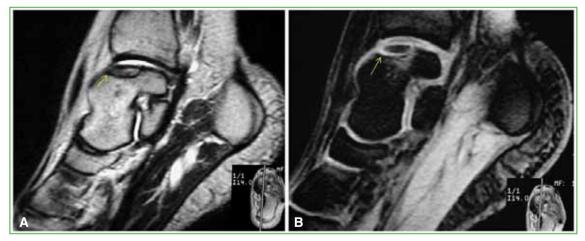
Sagittal T2-weighted (A) and T2-weighted fat-suppressed (B) MRI sequences revealing leakage of synovial fluid into the anterior side of the osteochondral lesion associated with minimal bone edema.
